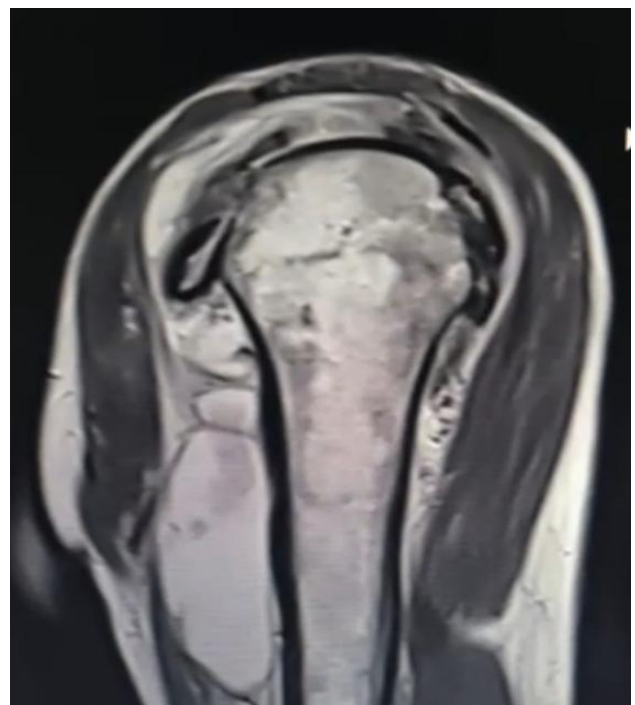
MRI of the right shoulder demonstrating complete proximal-third rupture of the long-head biceps tendon with surrounding fluid signal within the tendon sheath and glenohumeral joint effusion.
